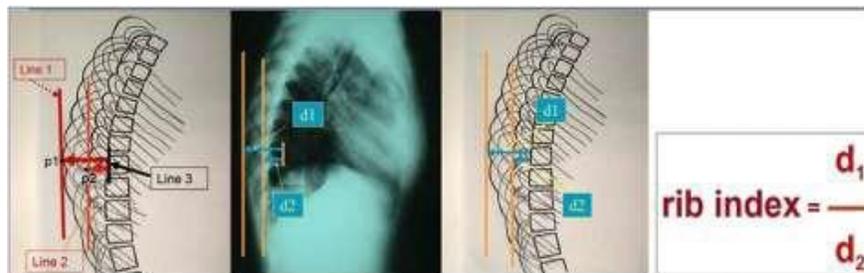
The DRCS of the RC in a spinal radiograph and the RI, (from Grivas 2014, [121]).
